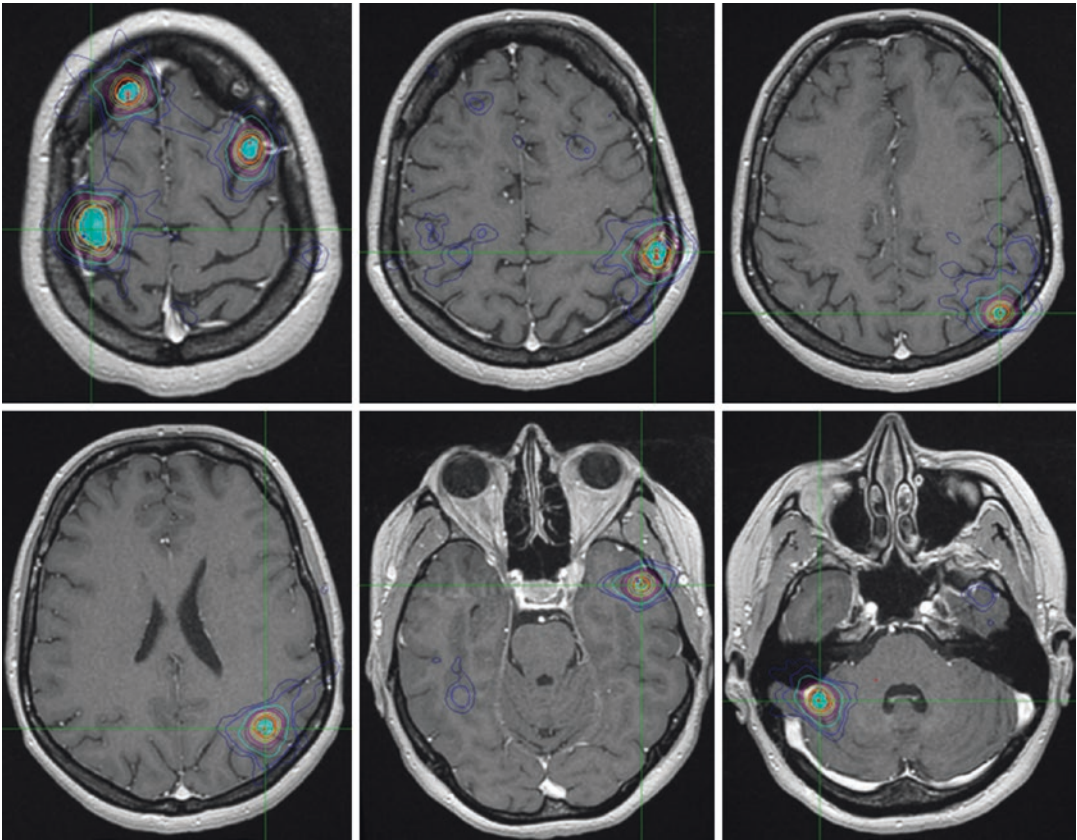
A 35-year-old patient in good health, treated 3 years before for slowly evolving metastatic lesions of a primary carcinoid carcinoma of the lung. Multiple surgeries for “focal” secondary sites in the breast, ovary, and skin; five already known brain metastases (< 5 mm each) controlled with different lines of chemotherapy. Recently: headache, diplopia, and a new MRI showing a progression
